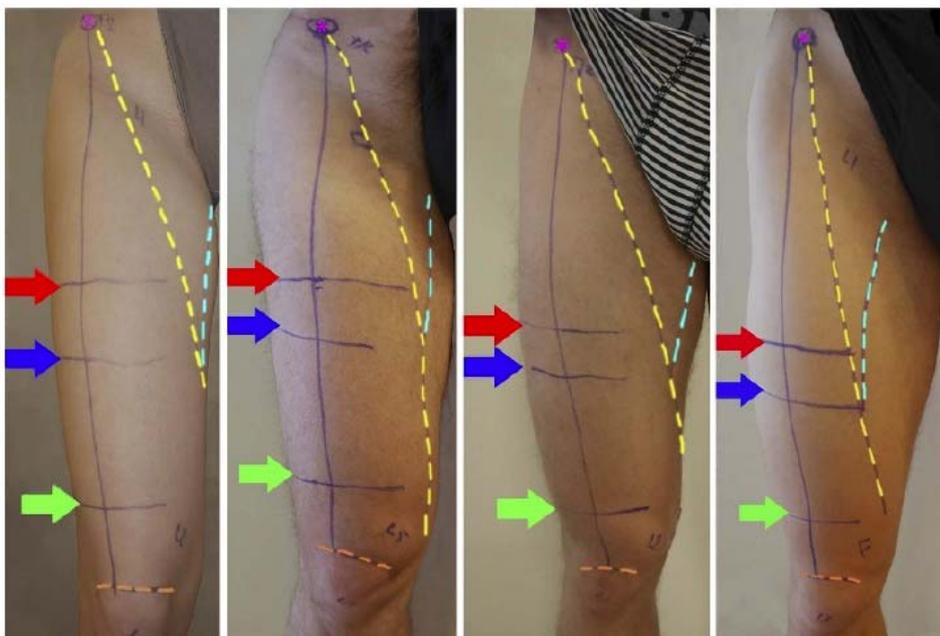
The figure shows the thighs of 4 volunteers. The midpoint of the thigh (red arrow) is defined as half the distance between the ASIS (pink asterisk) and the base of patella (orange stippled line) corresponding to the ultrasound images in Figure 1A. The proximal end of the AC (blue arrow) is defined by the intersection of the medial border of the sartorius muscle (yellow stippled line) and the medial border of the adductor longus muscle (cyan stippled line) corresponding to the ultrasound images in Figure 1B. The distal end of the AC is defined as the adductor hiatus (green arrow) corresponding to the ultrasound images in Figure 1C.
